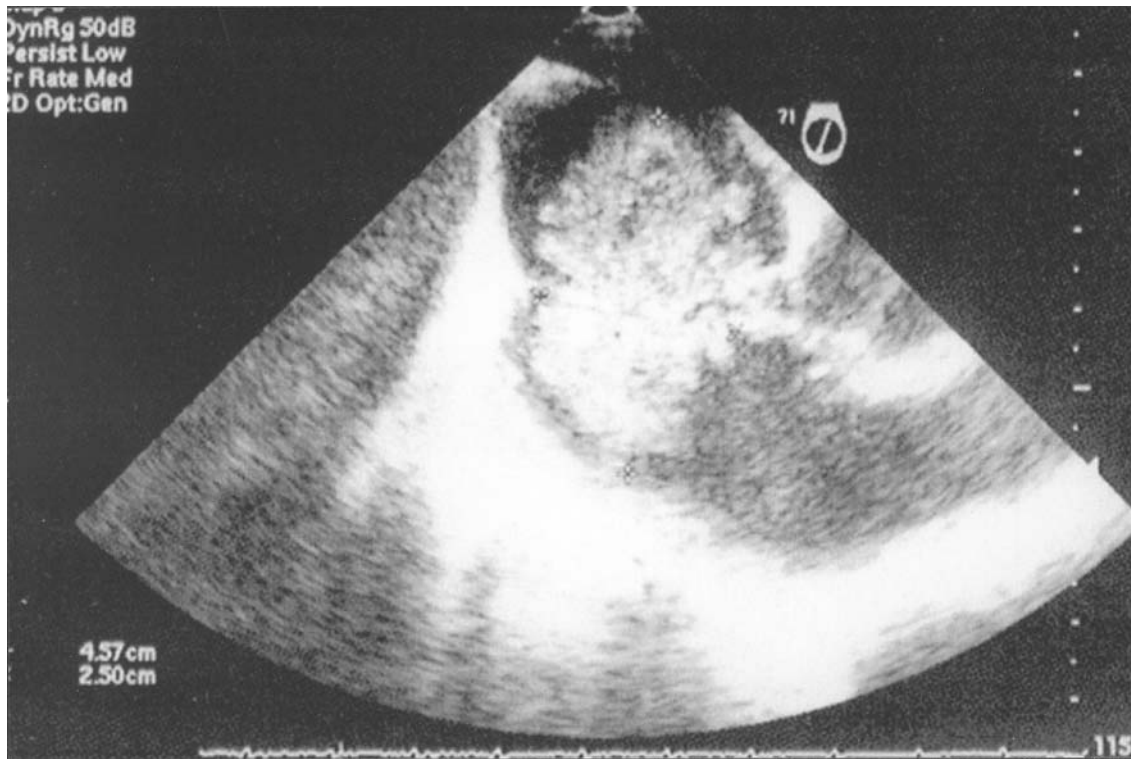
Trans-esophageal ultrasound. Mass of 4.6 x 2 cm attached to the right ventricle wall.*
